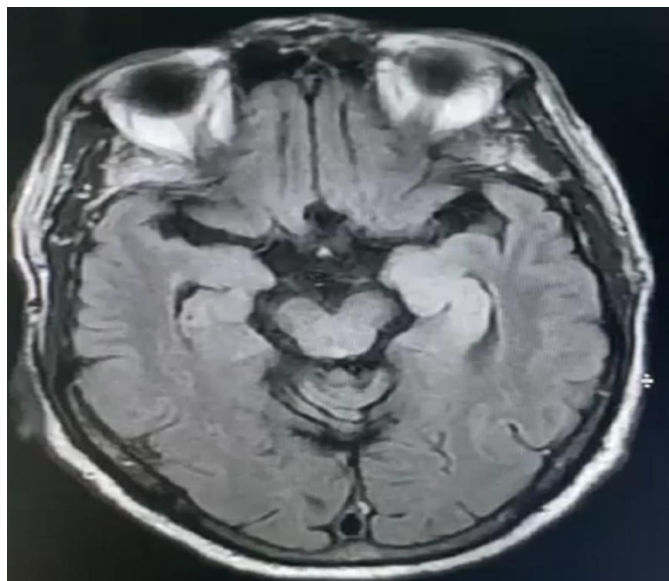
MRI Brain showing Left medial temporal lobe flair hyperintensity in a pateint of HSE
